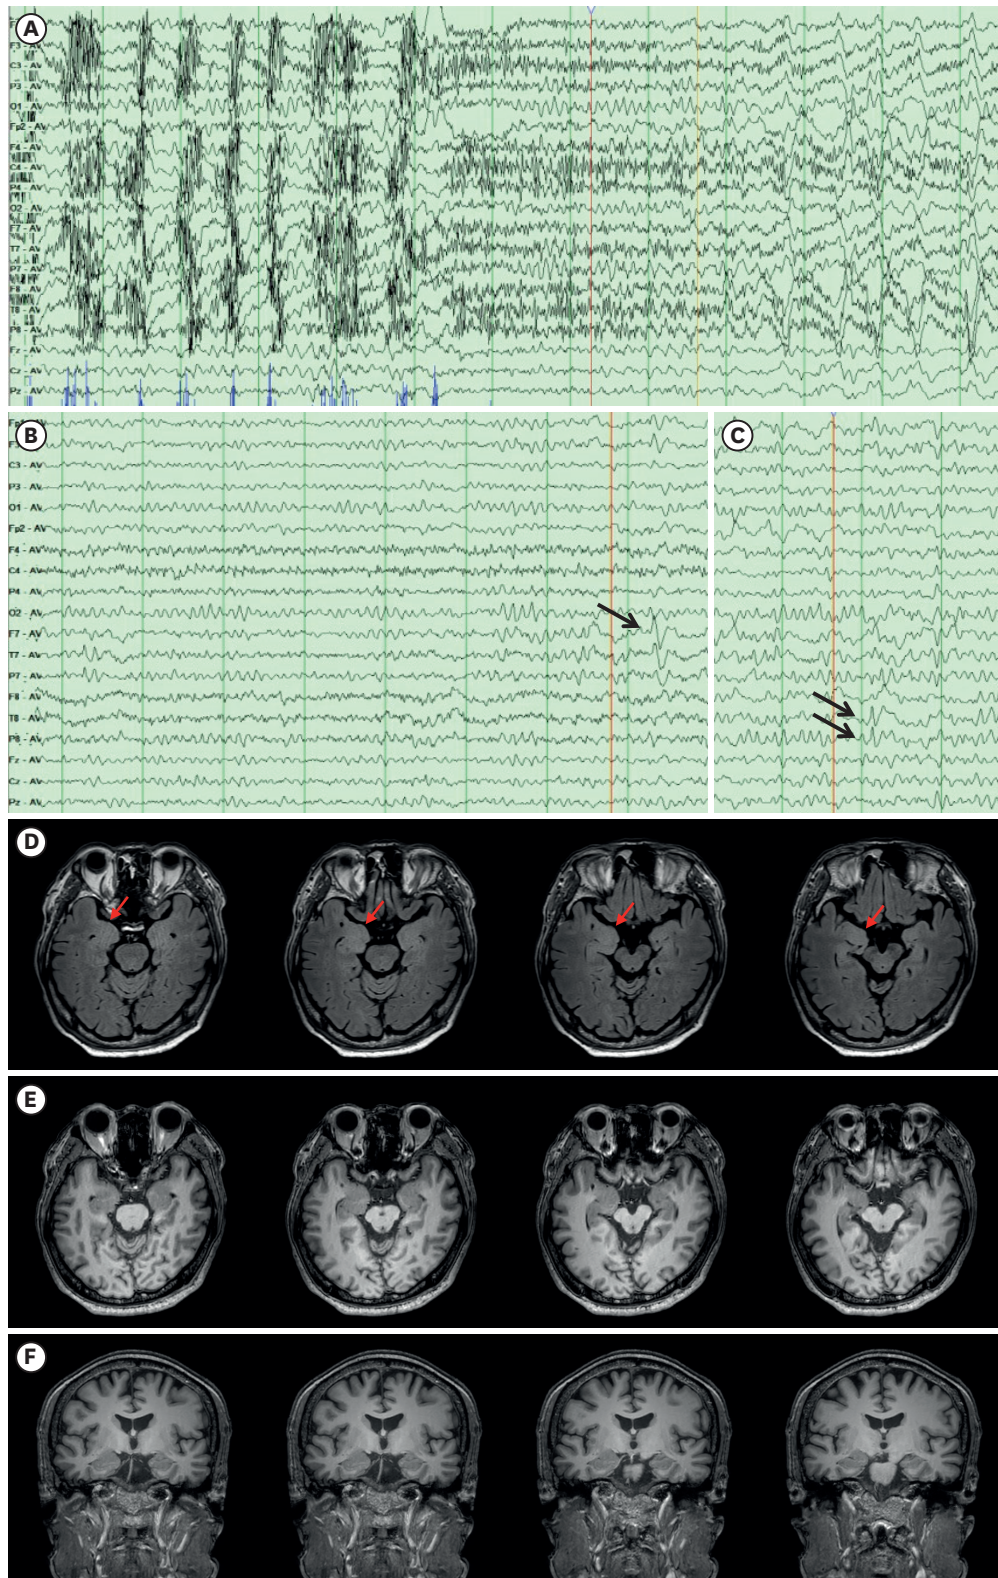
Overnight EEG video and brain MRI findings of the patient. The EEG captured one event of electrographic seizure, which originated from the right temporal area (A) and several interictal sharp waves (black arrow) in bilateral temporal (T8 or P8; F7) areas (B, C). Axial FLAIR images (D), axial T1-weighted brain MRI (E), and coronal T1-weighted brain MRI (F) showed amygdala enlargement (red arrow) with high signal intensity in the FLAIR images. EEG: electroencephalogram, MRI: magnetic resonance imaging, FLAIR: fluid-attenuated inversion recovery.
